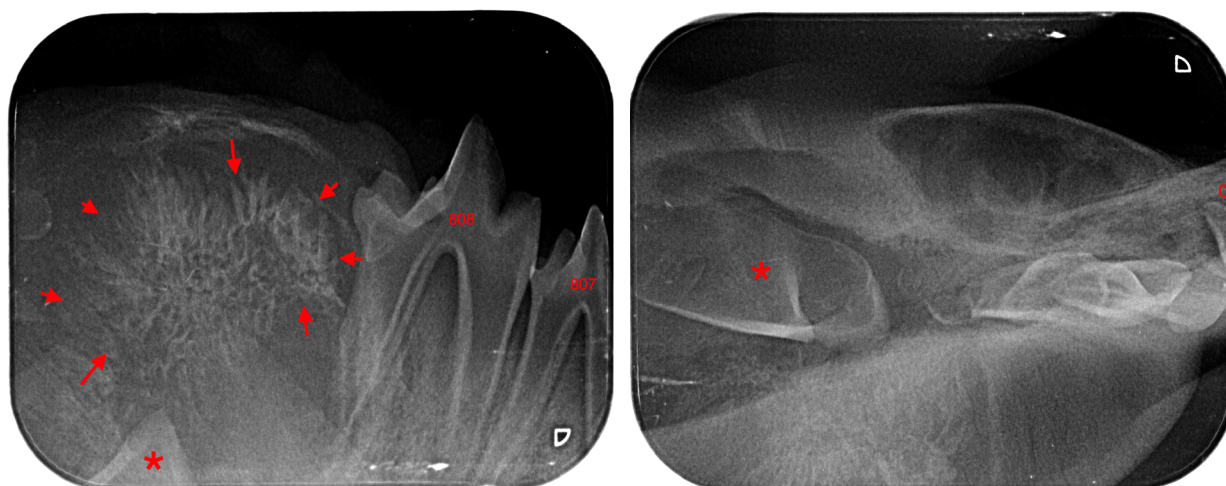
Radiography of the affected bone
